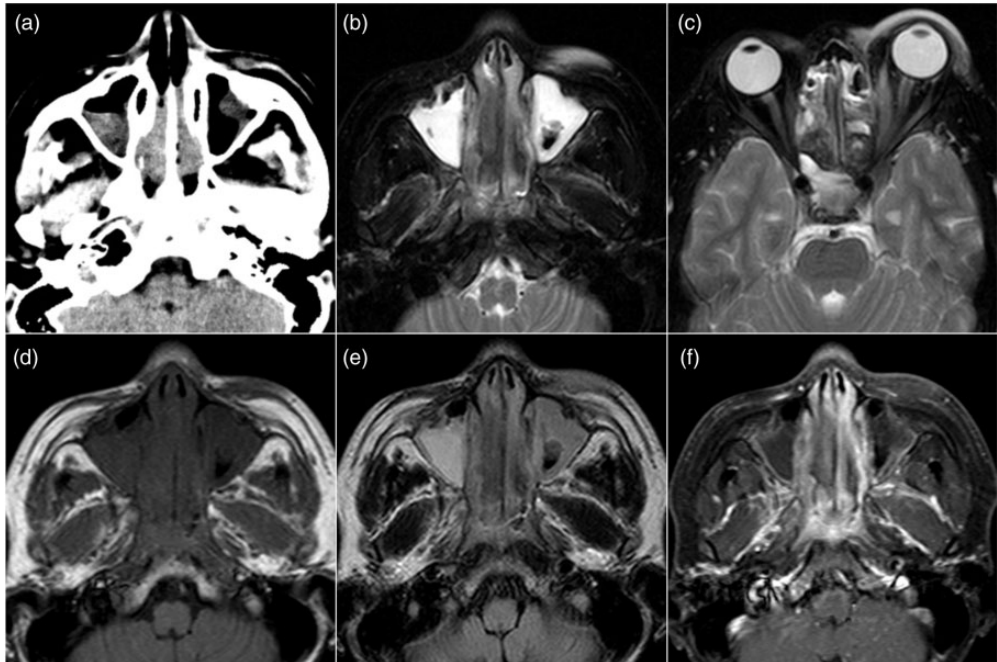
A 15-year-old male patient presented with a 17-day history of failing eyesight in the left eye. (a) Computed tomography images of the nasal lesion. (b, d, e, f) Magnetic resonance images of the nasal lesion (b, T2-weighted imaging; d, T1-weighted imaging; e, fluid-attenuated inversion recovery; f, contrast enhancement). (c) T2-weighted imaging shows edema of the left eyelid, enlargement of the right medial rectus muscle, and displacement and compression of the optic nerve.
